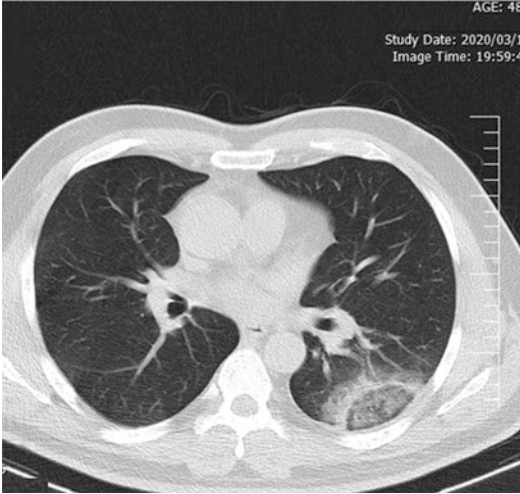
Axial chest CT scan without contrast in a 48-year-old male with COVID-19 pneumonia shows typical reversed halo sign at left lower lobe
